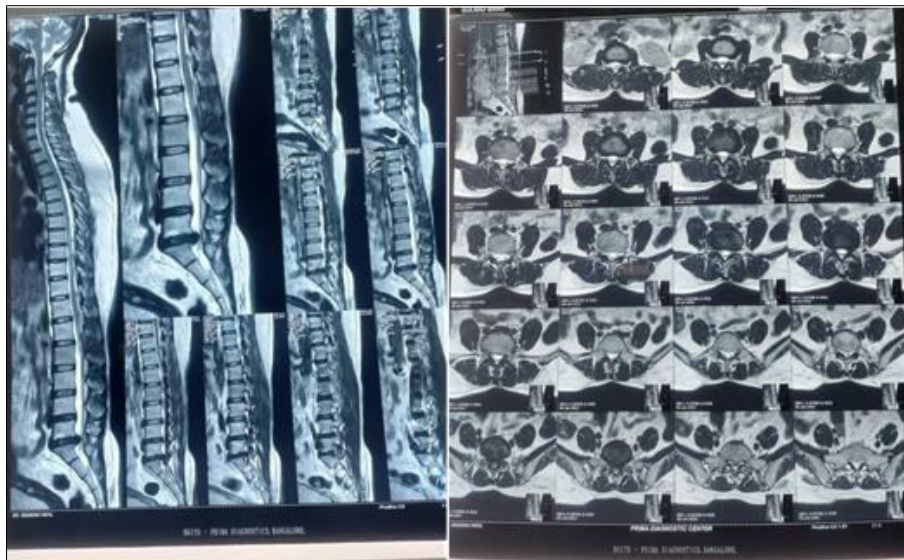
Pre operative MRI shows L5-S1 lumbar disc Herniation
